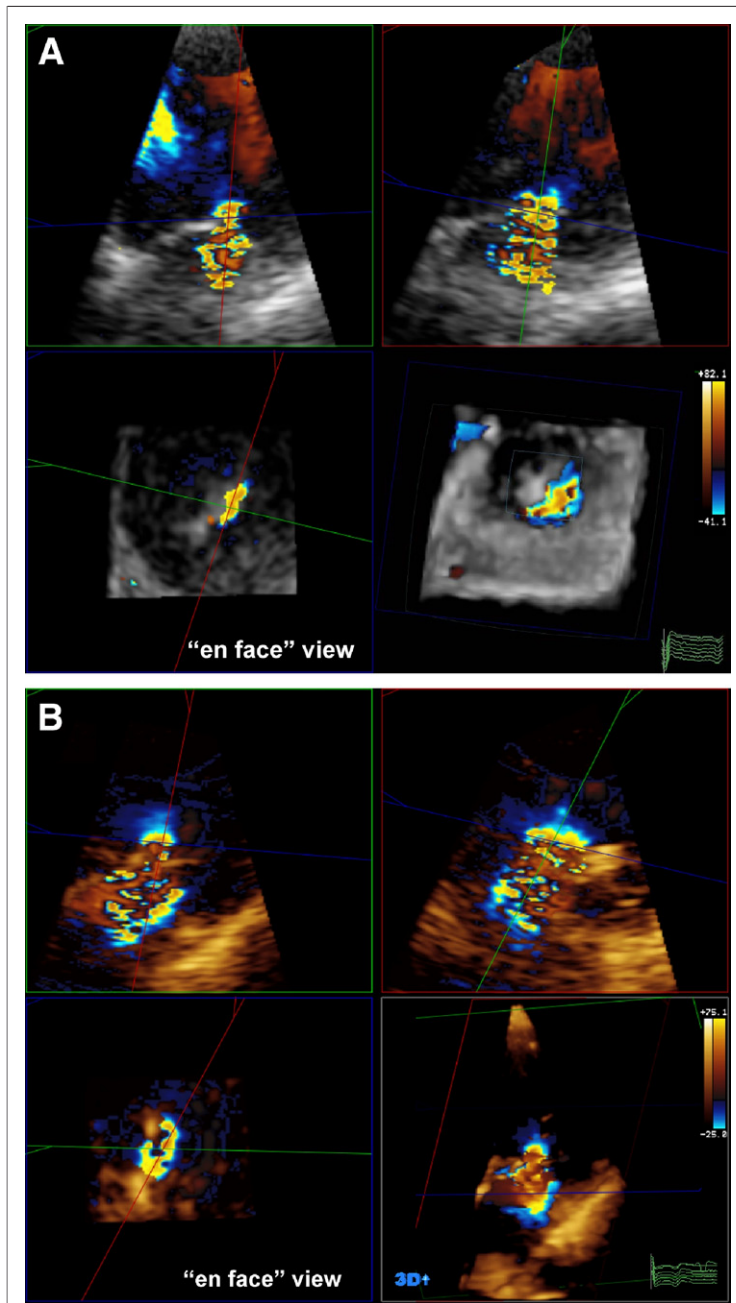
Real-Time 3D Echocardiographic Technique for Assessment of Vena Contracta Area (EROA-3D)
